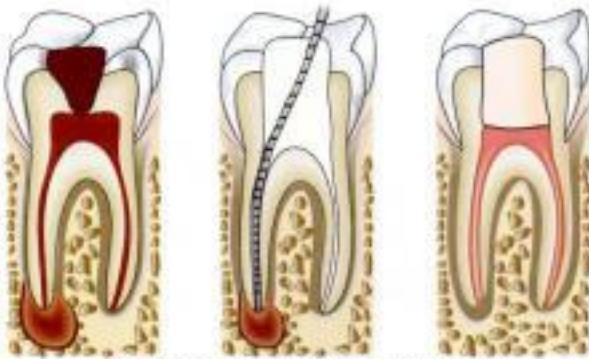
Management of periapical abscess
